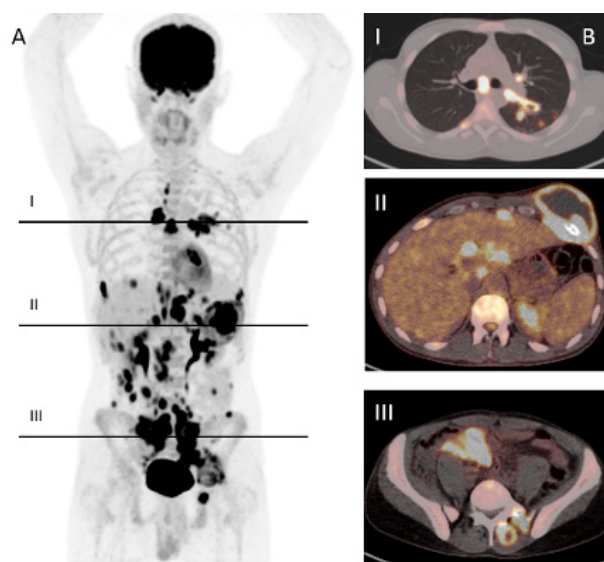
Case 1. A) The maximal intensity projection image and B) the corresponding fused ¹⁸FDG-PET/CT scan axial slices, demonstrated a distribution pattern highly suggestive of an advanced, aggressive neoplastic process with extensive involvement of supra- and infradiaphragmatic lymph nodes, as well as the liver, spleen, peritoneum, bone, muscle, and gastrointestinal tract. Additionally, imaging reveals findings consistent with left Nelson's bronchopneumopathy.
